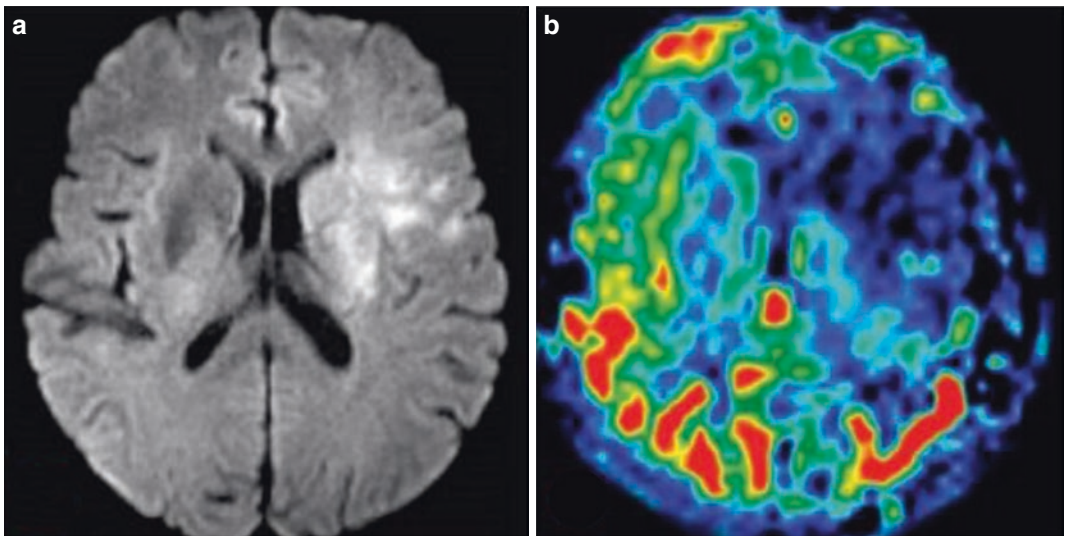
Acute cerebral infarction of the left frontal lobe and left basal ganglia. A 72-year-old female patient who presented with weakness in her right limbs and aphasia for 1 h. Transverse DWI shows acute cerebral infarction
